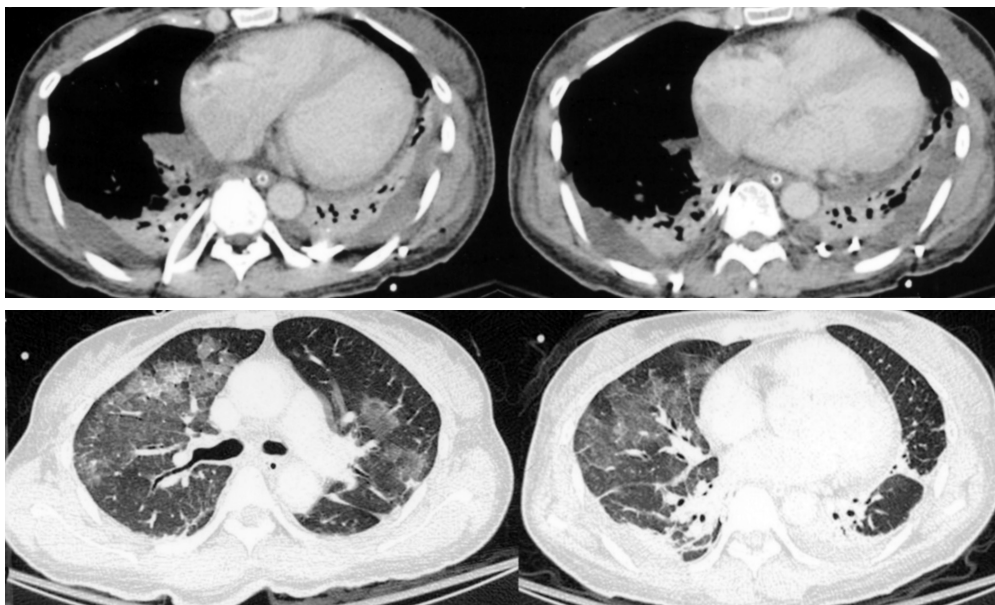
CT of the chest showing multifocal ground-glass opacity in the bilateral lungs, predominate at the right side, atelectasis of the bilateral basal lungs and a small amount of residual bilateral pleural effusion post-pigtail drainage.
